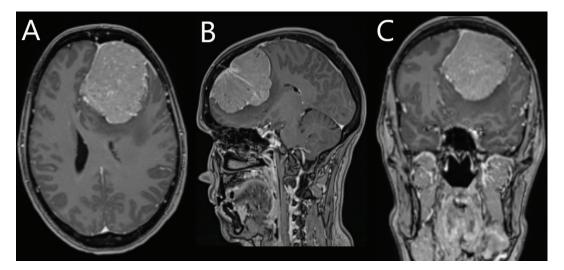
(A, B and C). MRI of the brain in T1 sequence of axial (panel A), sagittal (panel B), and coronal (panel C) sections with contrast enhancement (gadolinium) are shown. A hyperdense formation is seen, with multiple blood vessels and homogeneous filling of the latter, dural tail and imaging features of a meningioma
